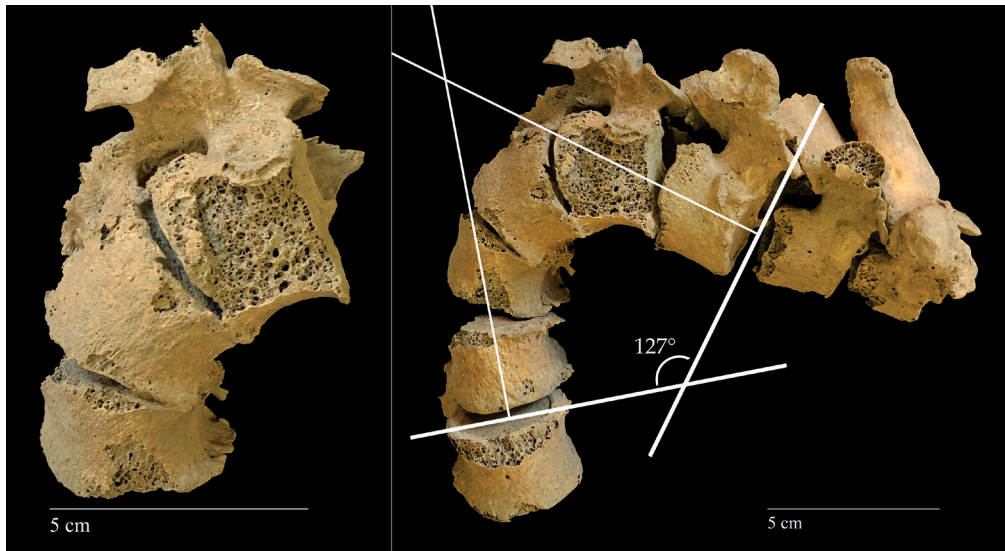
Scoliosis of the thoracic spine (left: anterior view of vertebrae T4-T5-T6; center: anterior view of the thoracic spine T1 through T8; right: plain radiograph of C7 through T6, showing no evident sign of fracture)
